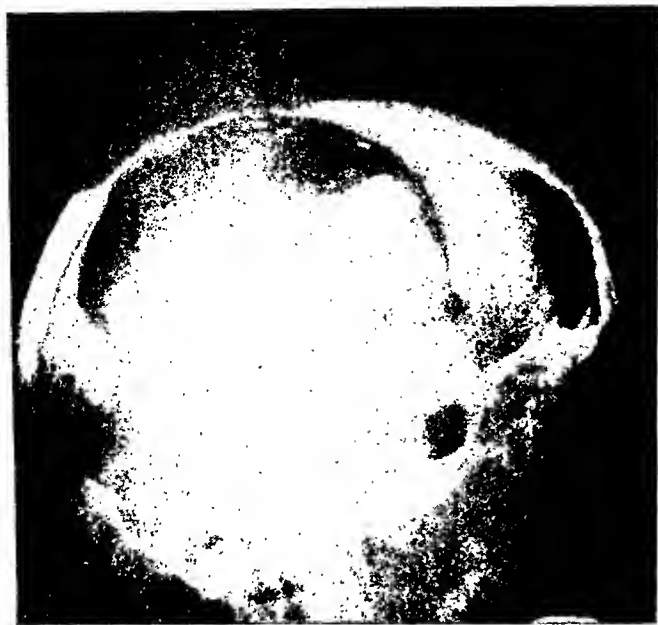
Case II: Roentgenograms showing numerous small, rounded regions of rarefaction, originally thought to be vascular anomalies.
